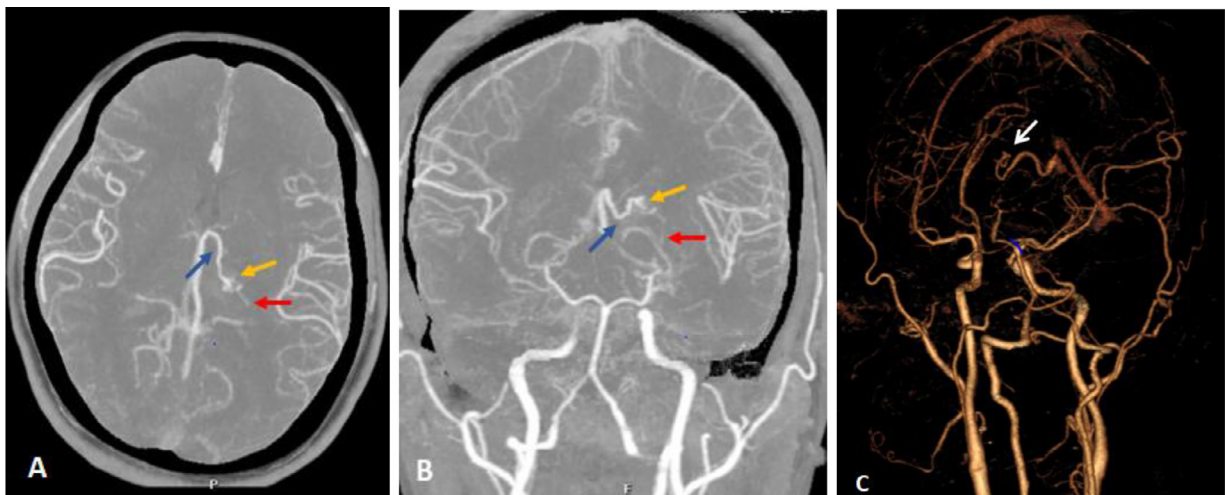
(A and B) CTA scan showing left thalamus arteriovenous malformation (AVM), pedicle from the thalamic branch of the left posterior cerebral artery (red arrow), nidus (yellow arrow), drainage to the left internal cerebral vein (blue arrow), (C) 3D rendering showing a small AVM (white arrow). (Color version of the figure is available online.)
